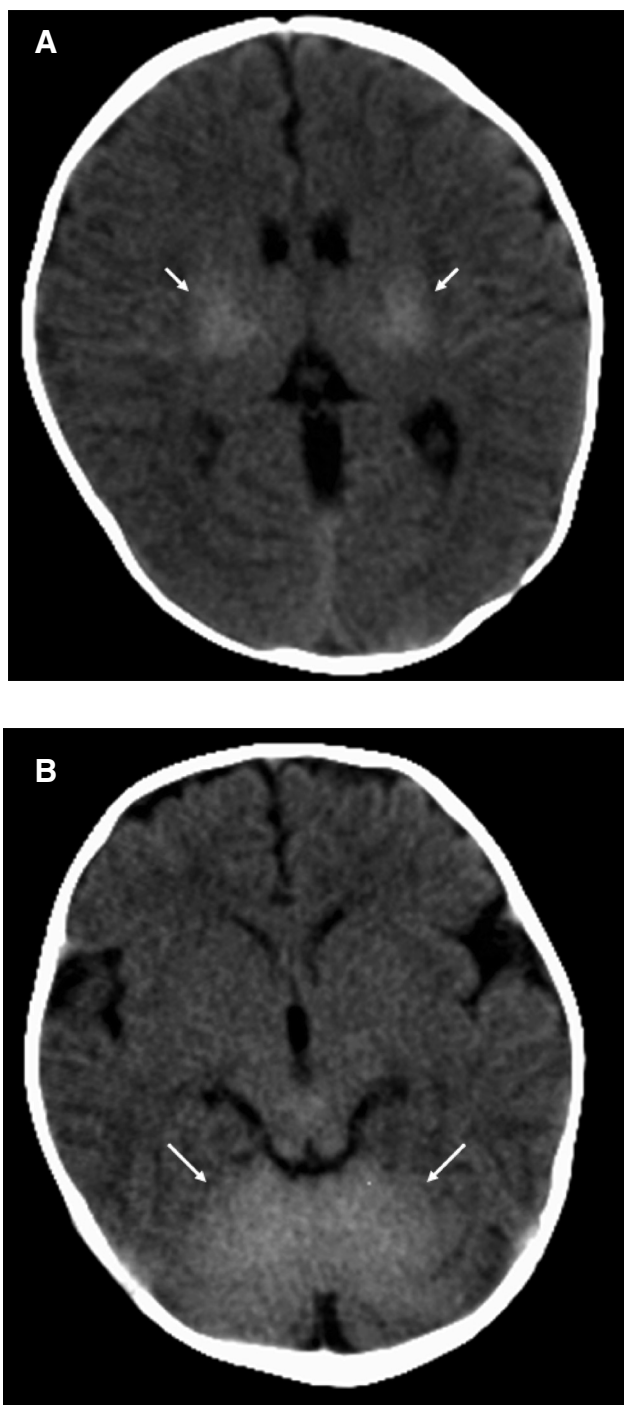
MRI showing signal abnormalities of the putamen and lateral thalami (A) and cerebellum (B).
